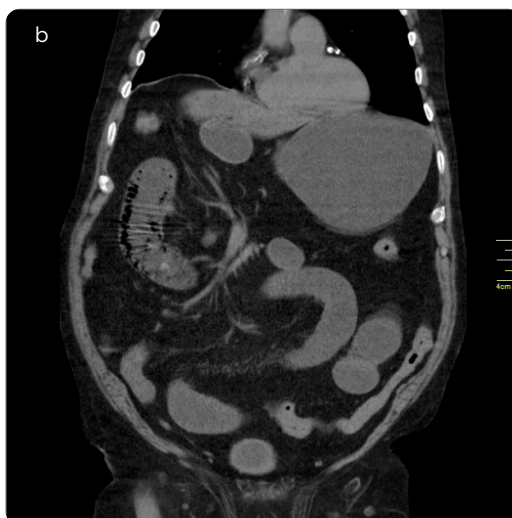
a and b) Simple CT of the abdomen, coronal: Distension of the middle small intestinal loops, with fecalization and collapse of small intestinal loops, due to high grade obstruction.
